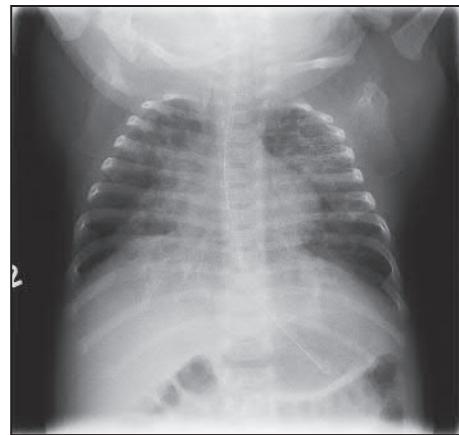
Chest X-ray of bronchopulmonary dysplasia (BPD) showing fibrosis and lung collapse, cystic changes and over-distension of the lungs.
